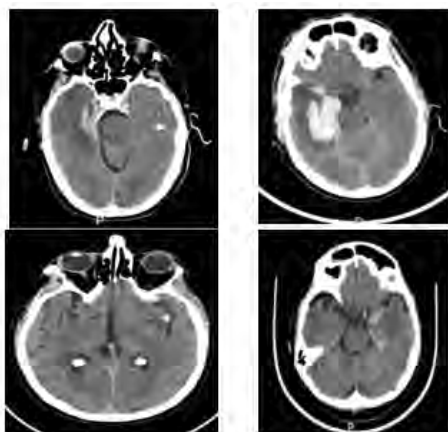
CT scan of patients with HSV1E with haemorrhagic lesions in neuroimage. In total, 7 of 20 people who had HSV1E presented with initial alterations in the CT scan, 5 of them with haemorrhagic lesions (A) Hypodensity within the right temporal lobe, with haemorrhagic signs at temporal medial level. (B) Right temporal haematoma with signs of herniation. (C) Hyperdense lesion within the cortico-subcortical left insular region. (D) SAH on both left temporal and sylvian fissure with intracerebral Figure 1
